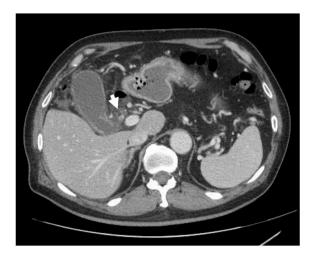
Abdominal computed tomography showing enlargement of the gall-bladder with wall thickening, stones in the gallbladder duct (arrow), and increased fatty tissue density around the gallbladder.
